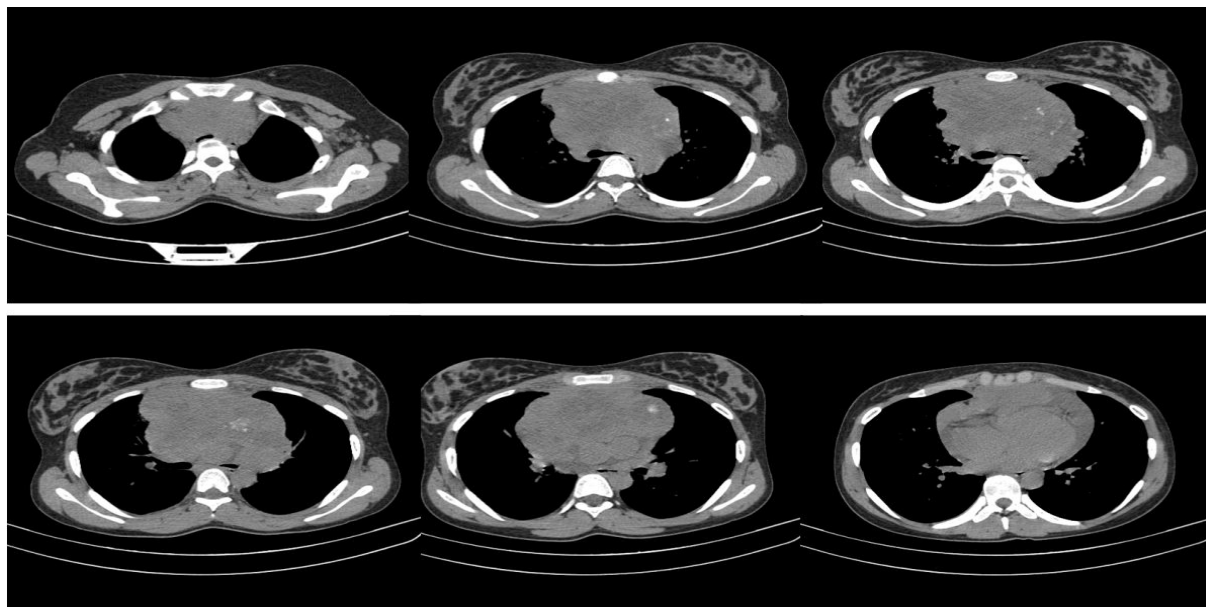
Thoracic CT demonstrating the presence of cervical and mediastinal compressive adenopathies
